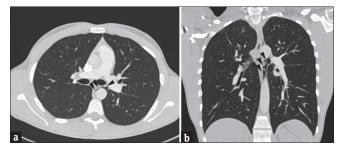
Axial (a) and coronal (b) reconstructed unenhanced CT images showing pneumomediastinum in the preaortic and subaortic spaces, respectively (white arrows)
